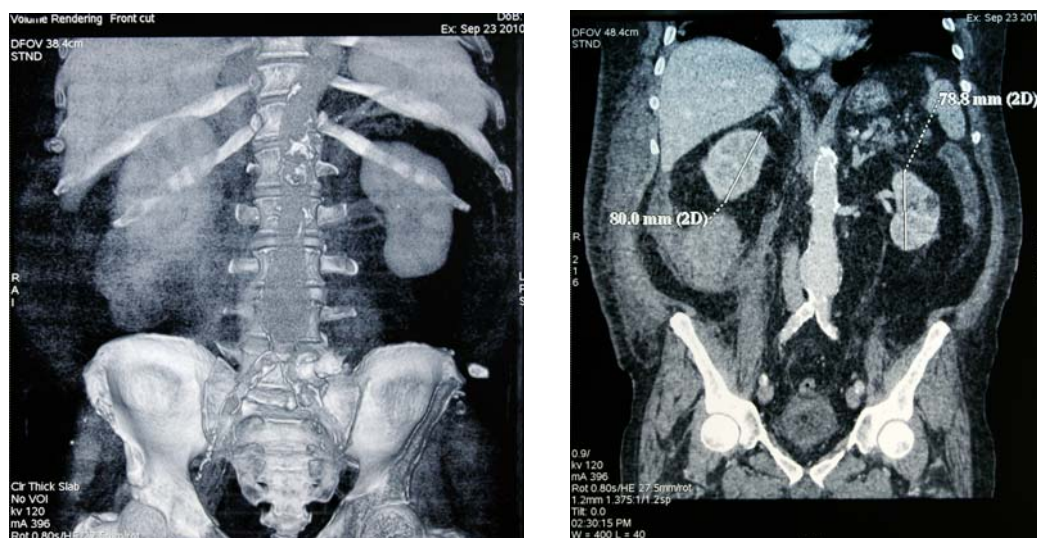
Computed tomography of the abdomen: retroperitoneal hematoma localized between the liver and the pelvis.
